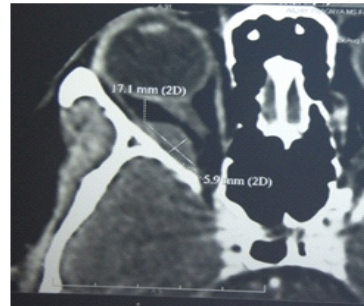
CT scan RT Orbit Thickened LR muscle
